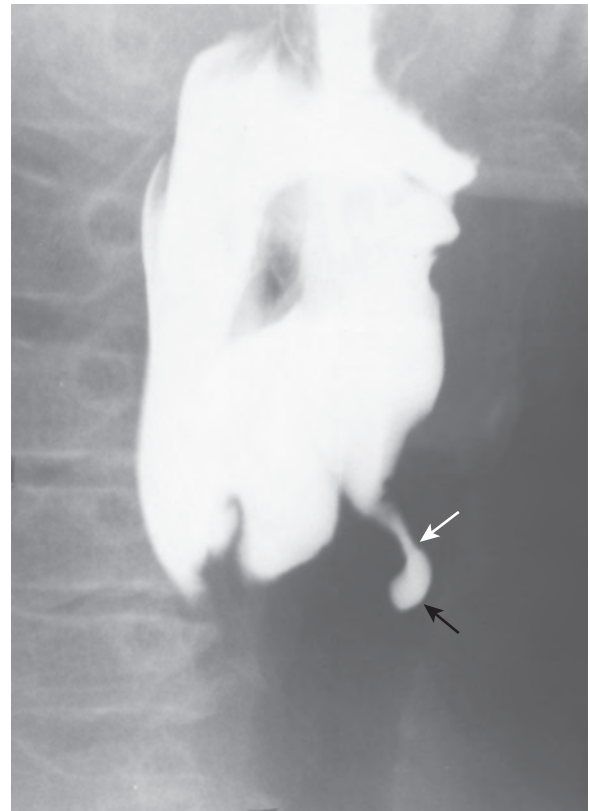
Fourth branchial pouch sinus. Spot radiograph of the pharynx obtained with patient in a left posterior oblique position shows a thin, 1.5-cm barium-filled track (white arrow) arising from the anterolateral wall of the lower left piriform sinus. The track has a saccular configuration at its termination (black arrow).
